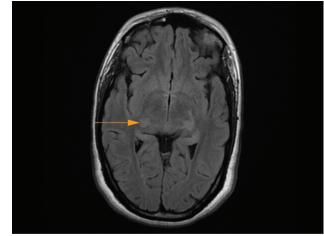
Axial T2WI-FLAIR sequence of MRI brain showing hyperintensities in the bilateral thalamus (lateral geniculate body) and hippocampus
